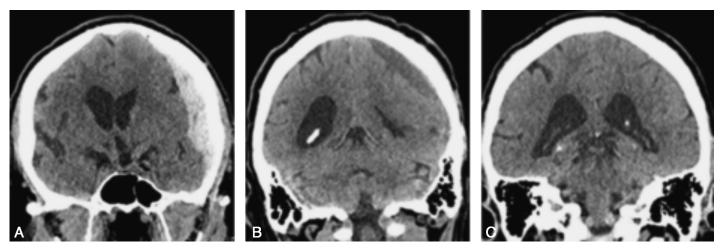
An 80-year-old man on warfarin presented with a left-sided subdural hematoma after falling. *A*, Frontotemporal craniotomy evacuation was performed. The patient was discharged to his facility but was readmitted with word-finding difficulties and mental status change. *B*, Head CT scan revealed the presence of a new cSDH. The patient was treated with MMA embolization. *C*, One-month follow-up imaging after MMA embolization demonstrated complete resolution of the hematoma.
